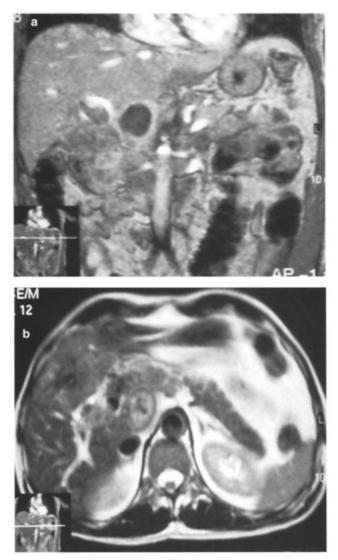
MRI. a) Coronal plane T1WI b) axial plane T2WI: central cholangiocarcinoma.
